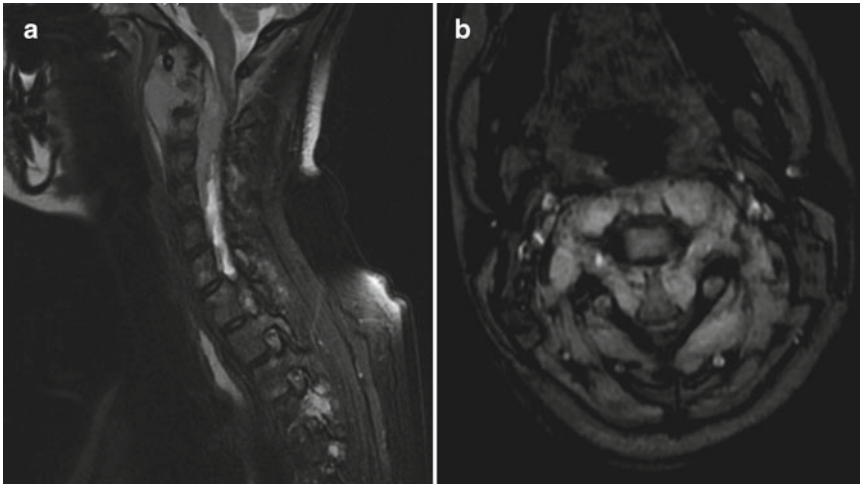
Sagittal T2 MRI (a) of the cervical spine shows tumor in the cervical ventral epidural space from C2-C5, and anterior to the body of C2. Pathologic analysis
